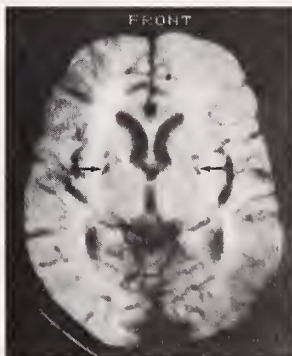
T1-weighted image demonstrating basal ganglia hypointensities.
